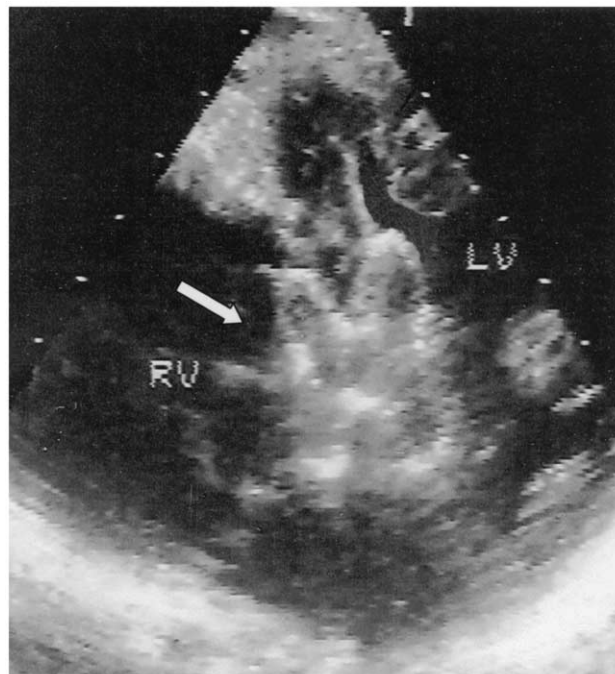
Transesophageal echocardiographic view of midmuscular ventricular septal defect closed with a 22-mm Amplatzer atrial septal defect occluder (arrow). (LV = left ventricle; RV = right ventricle.)
